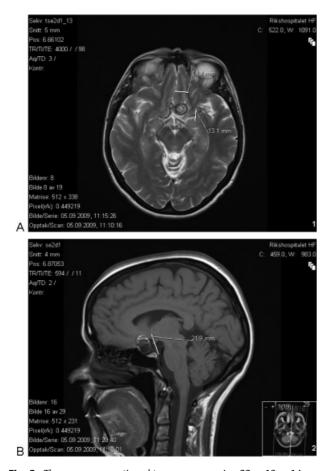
The aneurysm continued to grow, measuring $22 \times 13 \times 14$ mm 2 months post-coiling. (A) Axial T2-weighted magnetic resonance imaging (MRI). (B) Sagittal T1-weighted MRI.
